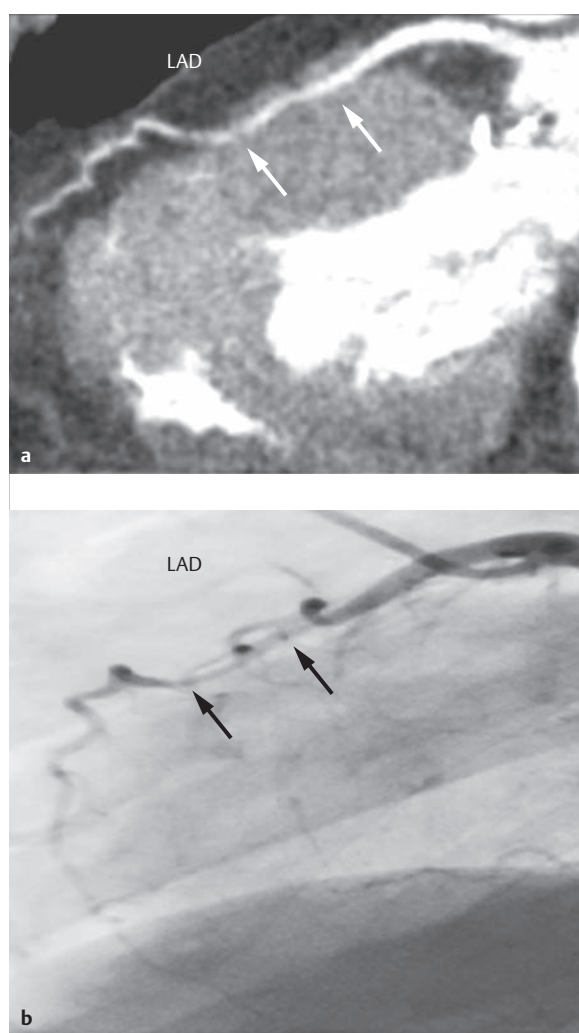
Myocardial bridge of the anterior interventricular branch. Seventy-year-old female patient with complaints of angina pectoris before a planned aortic valve replacement. The myocardial bridge (arrows) near the midventricular anterior interventricular branch can only be depicted indirectly using a cardiac catheter, but can be depicted directly using CT. LAD = left anterior descending artery
